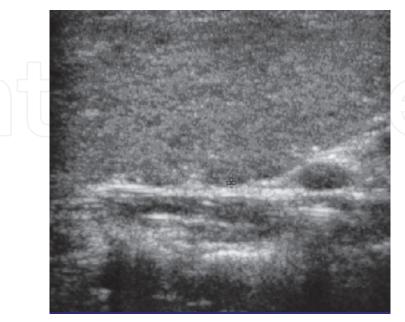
Hashimoto's thyroiditis: thyroid ultrasound showing hypoechogenicity
